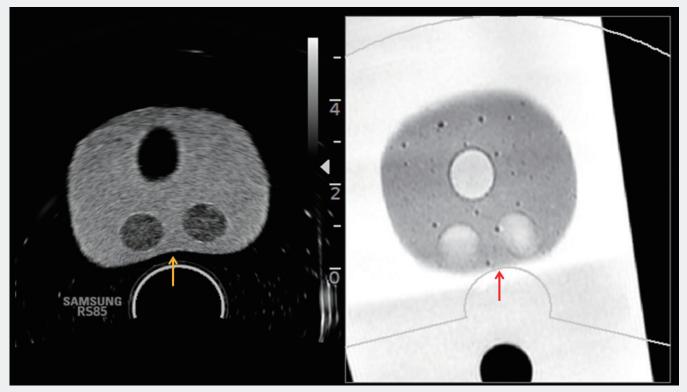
During the examination the probe compressed the prostate tissue (yellow arrow) and the result is a deformation of the prostate and a mismatch between ultrasound and MRI data (red arrow).
